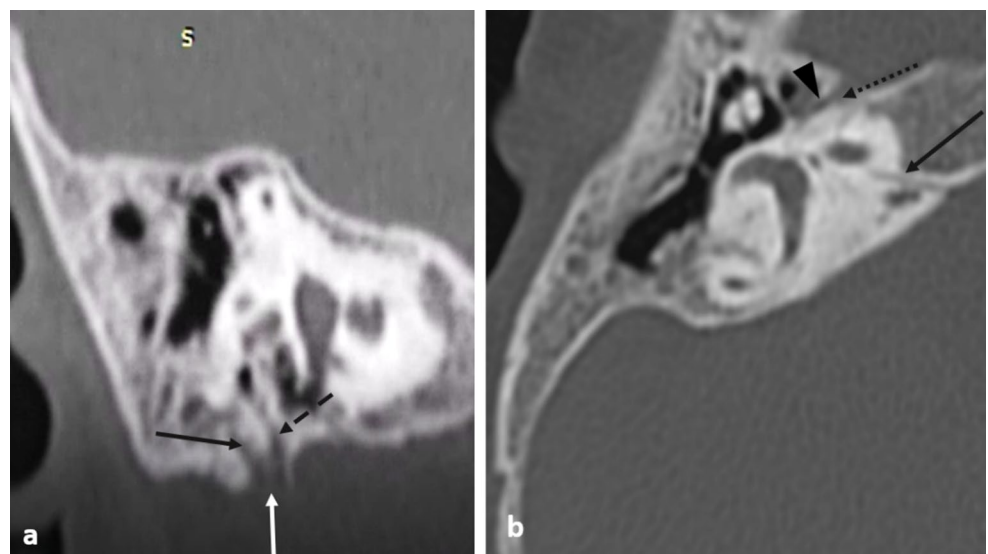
temporal bone CT scan bone of patient2 (a, b) and patient3 (c, d), axial slides a, b Anterior dislocation of the right labyrinthine segment of the right FN (a: black arrow), with a bilateral hypoplasia of the geniculate ganglion (dashed black arrow), we note a bilateral cochlear aplasia with a dilated vestibule (empty arrows), the right tympanic segment (thick black arrow), and the greater petrosal nerve (arrow head). c, d: anterior dislocation of the labyrinthine segment of the right FN (c: black arrow), we note a hypoplasia of the geniculate ganglion (dashed black arrows). The left labyrinthine segment is represented by a black arrow and the greater petrosal nerve emerging from the tympanic segment of the FN is shown by an arrow head
